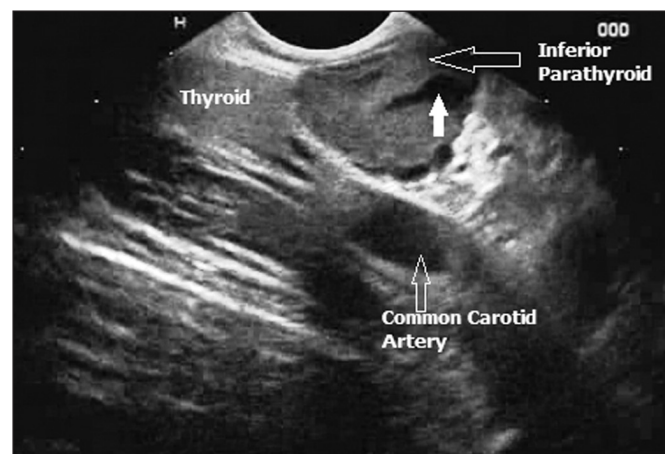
Endoscopic ultrasound: Well-defined heterogeneously echotextured lesion located posterior to the inferior border of the thyroid lobe. Cystic area is seen in the lesion (white bold arrow)
